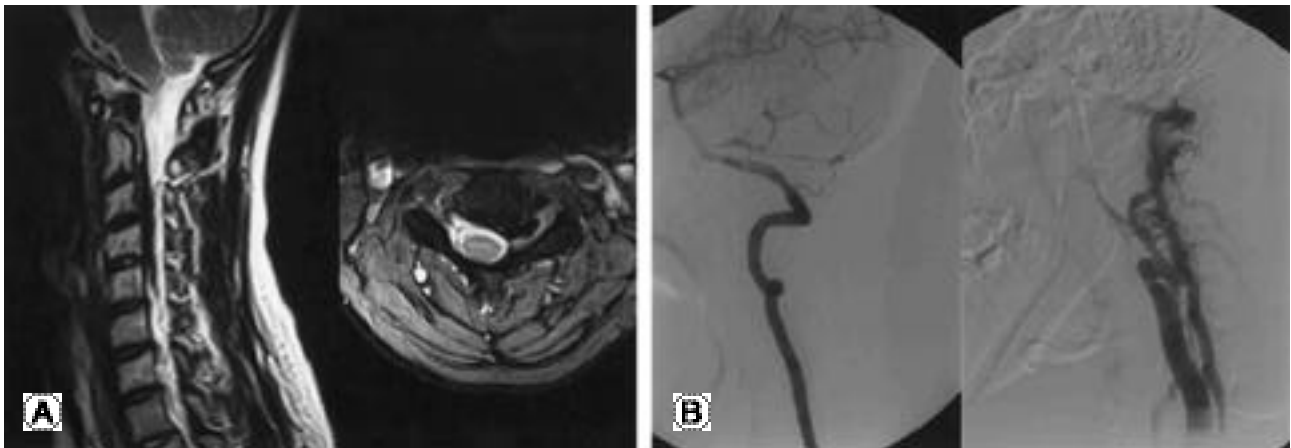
(A) Pre-embolization MRI at C3-4 level. The cervical dura is compressed by dilated, engorged epidural veins and feeding artery is located in the left C 3-4 intervertebral foramen. (B) Left vertebral angiography shows cervical vascular abnormality comparing to normal right side vertebral artery.
